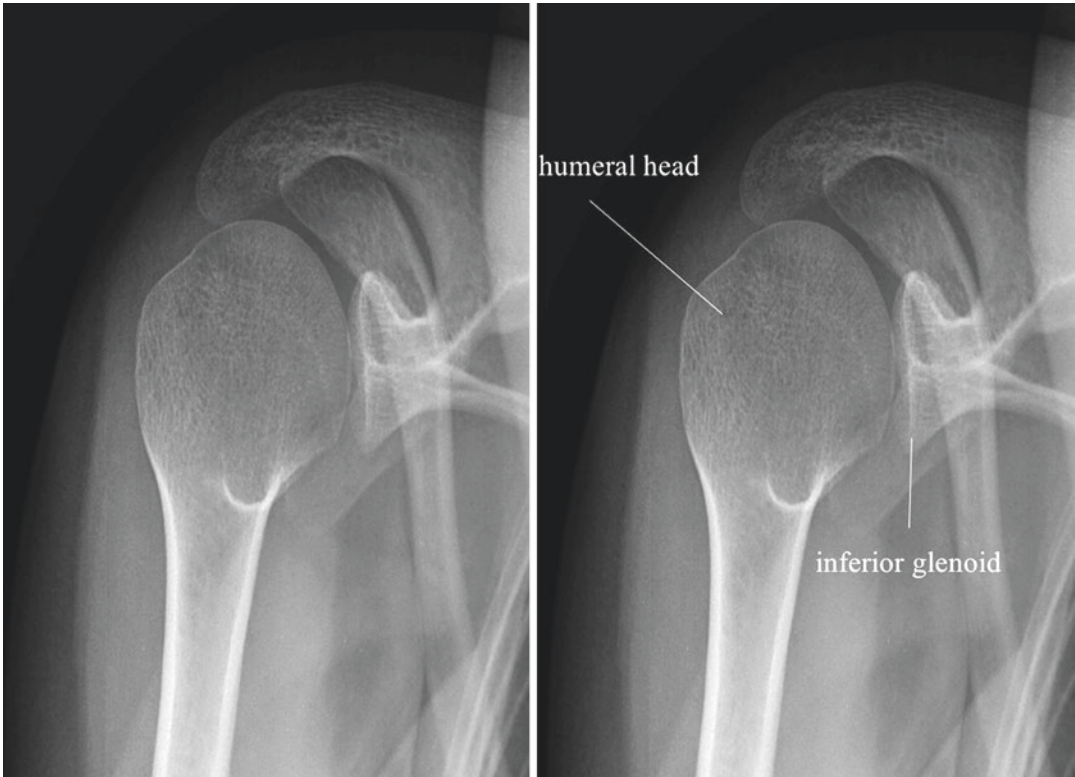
Anteroposterior shoulder radiograph in internal rotation. Patient is either erect or in supine position. In order to position the shoulder in internal rotation, the posterior aspect of the hand is placed against the hip. Anteroposterior shoulder radiograph in internal position
